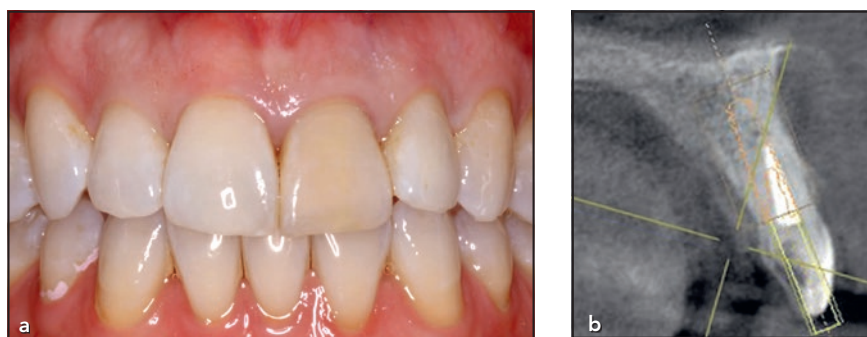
Case 2. (a) Pretreatment condition of the maxillary left central incisor that had previous endodontic therapy and tooth discoloration. A 7.0 mm mesiobuccal probing depth was measured. (b) A cross-section of a CBCT scan taken before treatment shows root fracture and the facial root position with minimal labial plate dimension.
